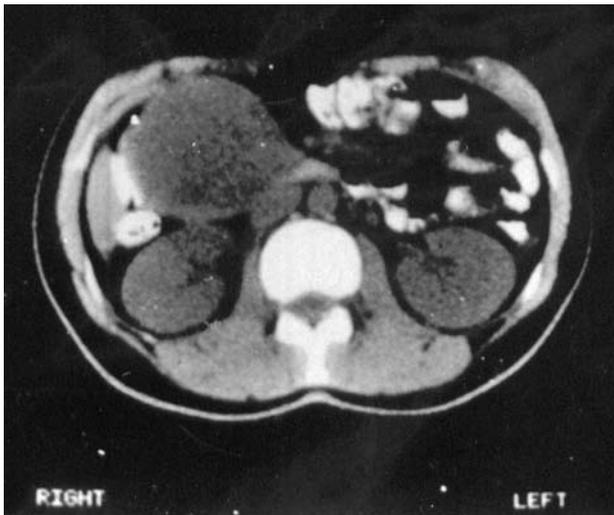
Computed tomography showing a cystic lesion of the head of the pancreas, 18cm in diameter.
